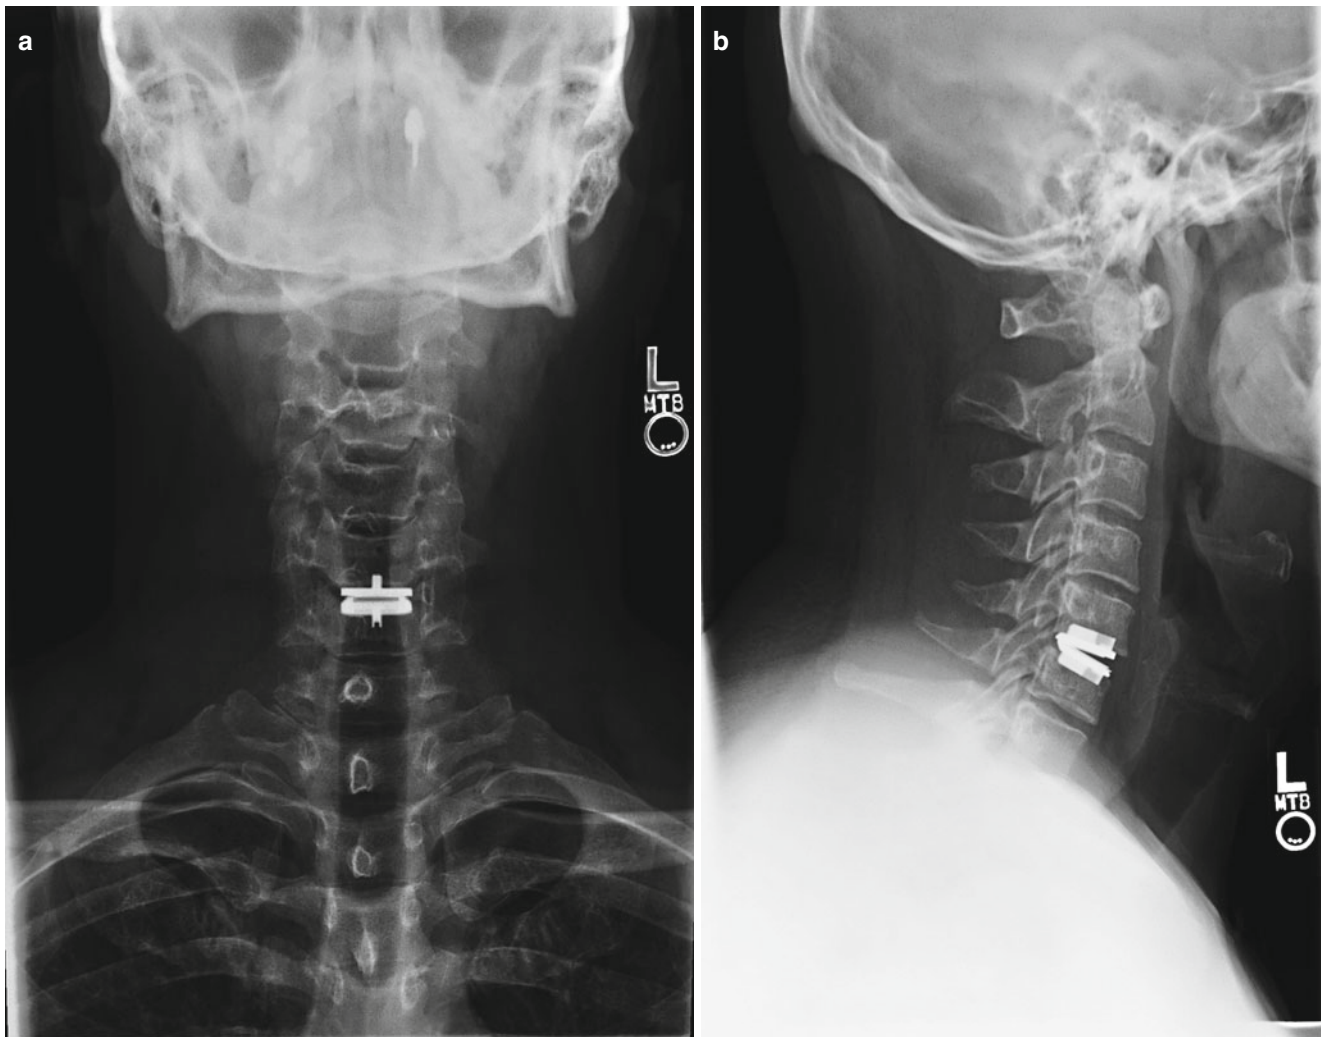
(a, b) Radiographs of patient with single-level ProDisc-C device
